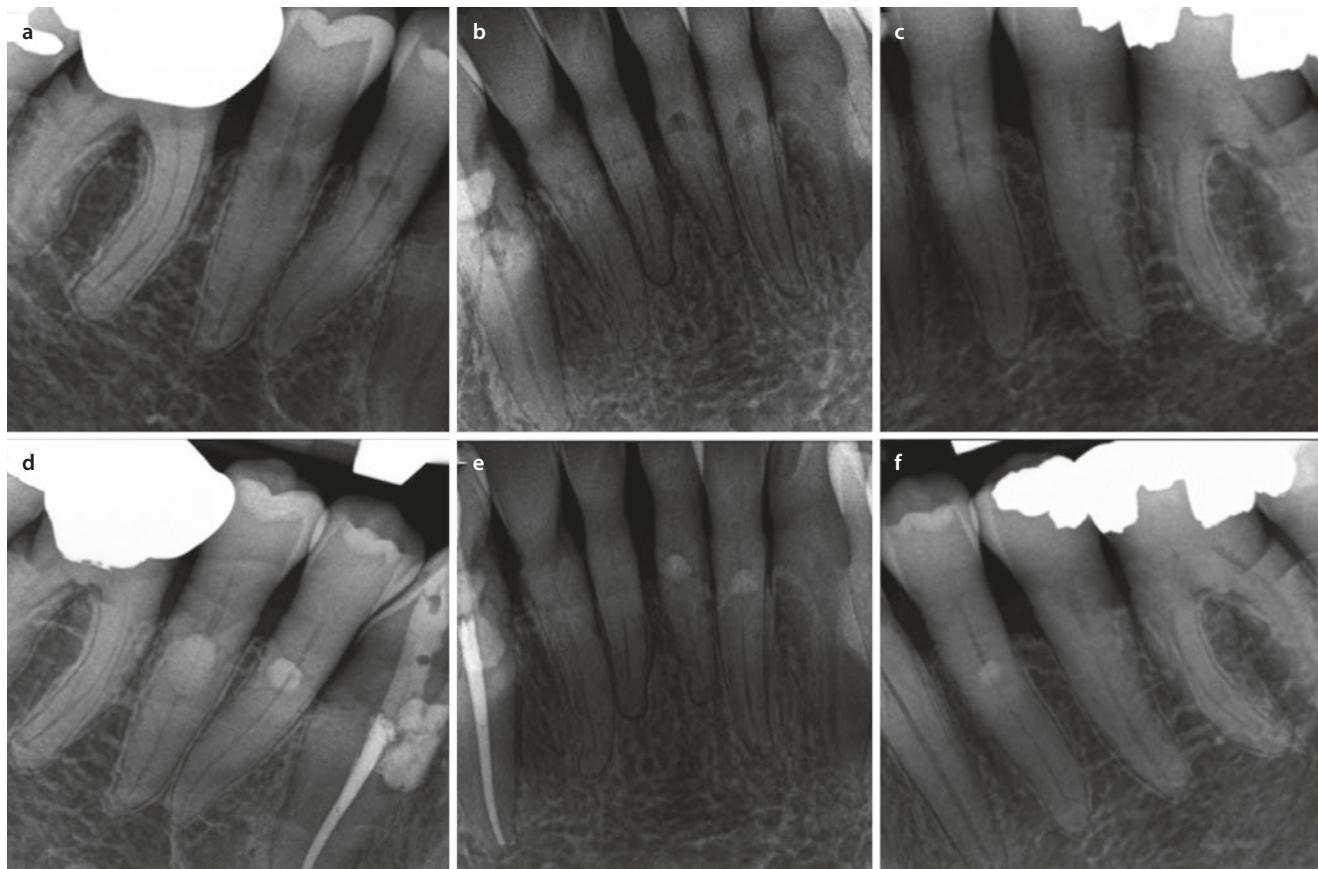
a–c Pre-operative radiographs showing Class 1–2 ICR on teeth #21, 23, 24, 27, 28, & 29. d–f Endodontic treatment was completed in multiple visits for tooth #27. A surgical approach was
